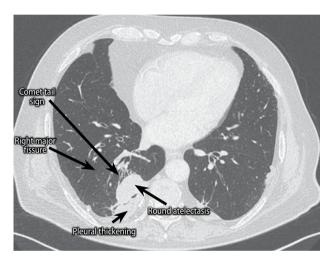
Blesovsky syndrome with the 4 characteristic radiographic findings: i) oval mass that abuts the pleura, ii) adjacent pleural thickening, iii) comet tail sign, iv) volume loss of the involved lobe.
